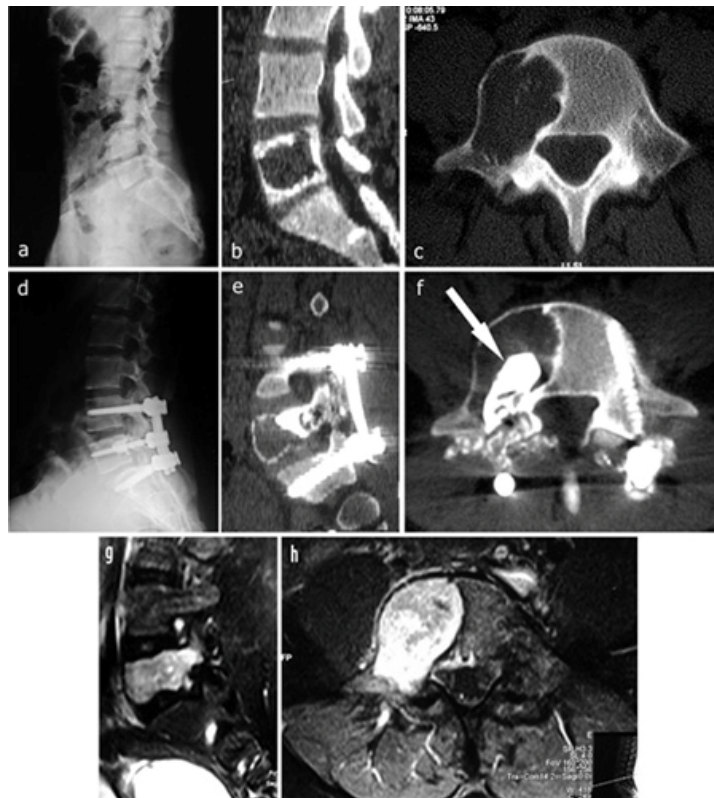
The patient's preoperative plain lumbar (L) radiograph and lumbar computed tomography scan with sagittal reconstruction show a hypodense area in the posterior portion of the L5 vertebral body, and the cystic lesion with sclerotic well-demarcated wall in the right half of L5 extending to the right pedicle (a, b, c). Postoperative plain radiograph and computed tomography scan of lumbar vertebrae with sagittal reconstruction show the region after L5 laminectomy, careful curettage leaving the cortex intact, and bilateral L4, S1, and left L5 transpedicular instrumentation (d, e) with right L5 vertebroplasty (f- white arrow). Preoperative T1-weighted magnetic resonance imaging after intravenous gadolinium injection (g, h) revealed diffuse homogeneous enhancement of the lesion
